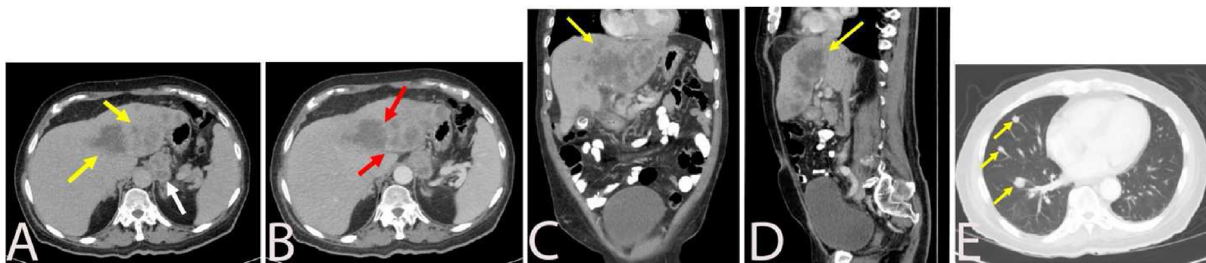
A, B, C and D are images of CT abdomen with intravenous contrast. A is an axial image in the portal venous phase showing multiple, ill-defined, hypodense lesions in the left hepatic lobe and medial right hepatic lobe with irregular margins (yellow arrows). A conglomerate of enlarged celiac lymph nodes are also seen (white arrows). B is a delayed image demonstrating subtle rim-enhancement of the hepatic lesions (red arrows). Image C and D show the hepatic lesions (yellow arrows) in coronal and sagittal views respectively. E is an image of CT chest with contrast showing metastatic nodules in the right middle and lower lobes (yellow arrows).
